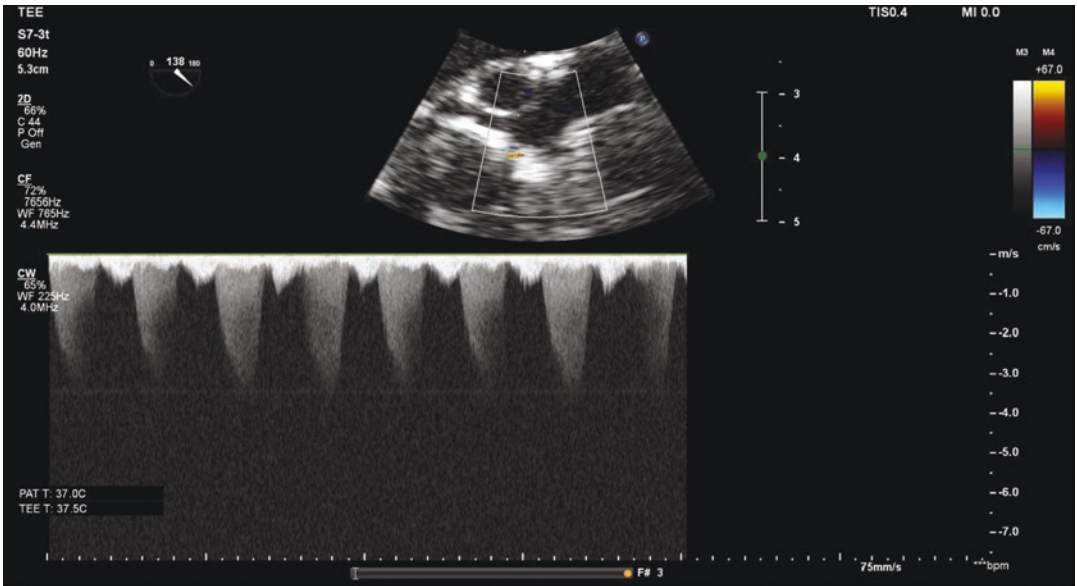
Continuous wave Doppler recording through the residual VSD jet identified in Fig. 5. Note the high velocity, which is consistent with the expected low RV systolic pressure following VSD closure
